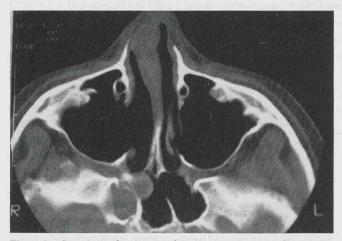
Case 1: At four-month follow-up, recurrence of the polyp was observed in an axial CT-scan section. An opacity of the right sphenoethmoidal recess and the right sphenoid sinus is found. The maxillary antrum was normal and sufficiently enlarged.
